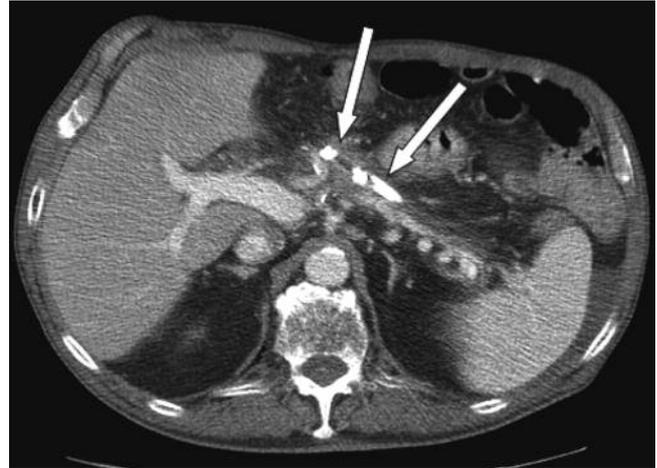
The latest low-dose CT control, three months later on outpatient status, showing the disappearance of the collection (arrows).
